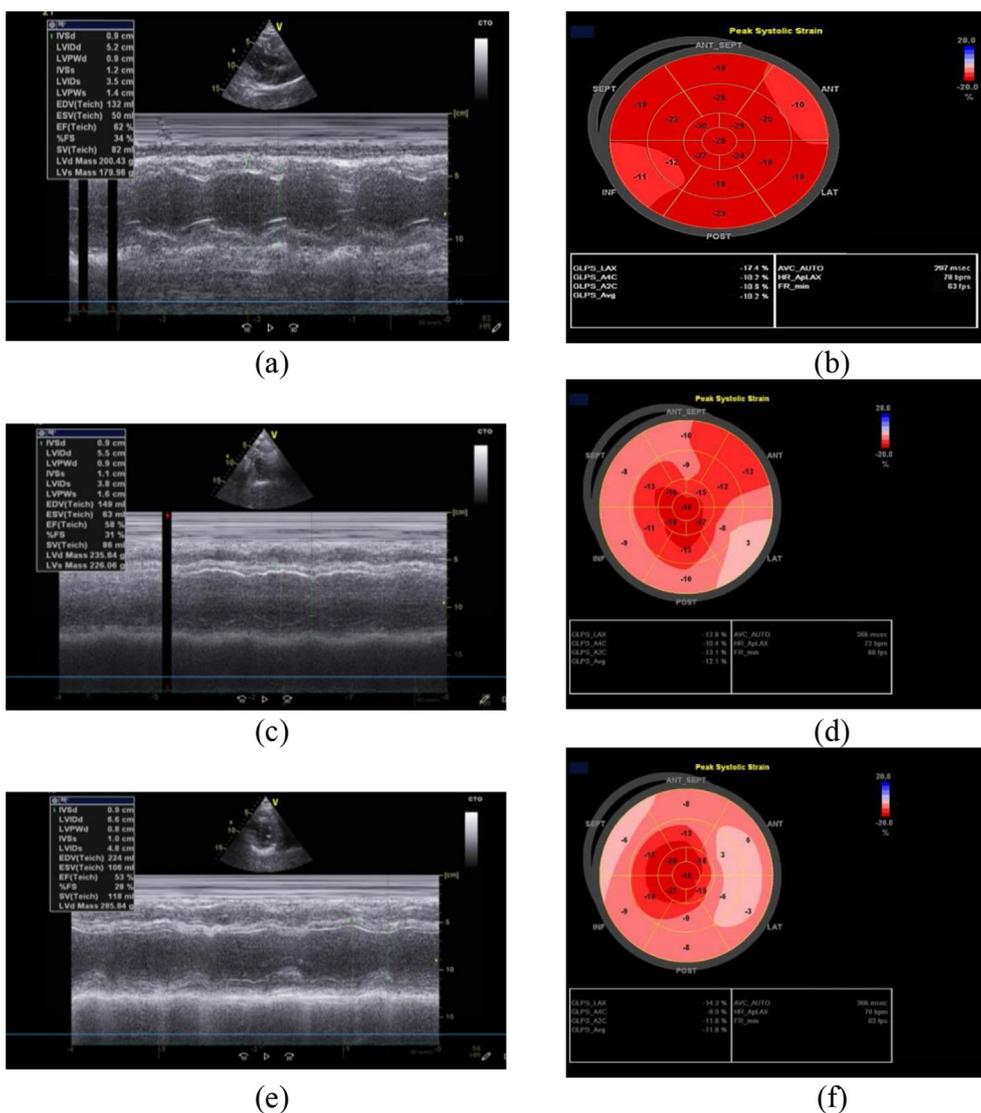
Male patient aged 58 years, known to be hypertensive and smoker, not known to be diabetic or cardiac before, he denied having any thyroid or chest problems, He had average BMI=23kg/m<sup>2</sup> diagnosed as lymphoma. He was planned to receive doxorubicin. On the first visit (V1): (a, b): baseline echocardiography showed no significant abnormal echo-doppler data, EF=62%, and GLS=-18.2%. On the second visit (V2): He received a cumulative dose of 276 mg/m<sup>2</sup>, no complaint, Echocardiographic examination (c, d) showed: EF=58%, GLS=-12%, AbGLS= 6.2 and  $\Delta$ GLS=34% (Subclinical cardiotoxicity). On the third visit (V3): Cumulative dose of doxorubicin= 457mg/m<sup>2</sup>, complaining of dyspnea grade III, echocardiographic examination (e, f) showed: , Ef=53%, GLS=-11.6%, AbGLS=6.6 and  $\Delta$ GLS=36.2% (Cardiotoxicity occurred). (a, c, e): 2D echocardiographic examination for assessment of LVEF by M-mode. (B, D, F): Strain echocardiography examination to measure GLS showing Bull's eye.
